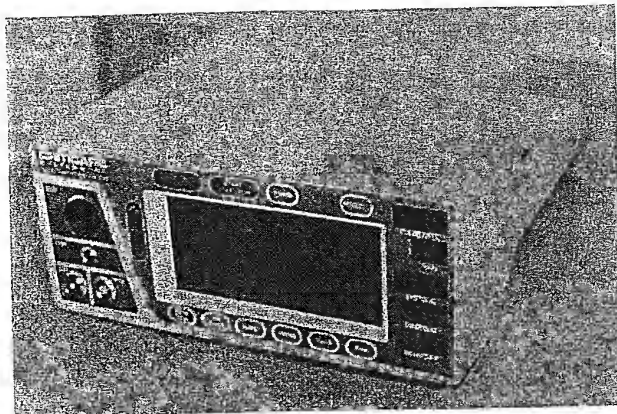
Multiple monitor appropriate for liposuction measures blood pressure, pulse, oxygen saturation, and echocardiogram. Body temperature monitor available as well.
